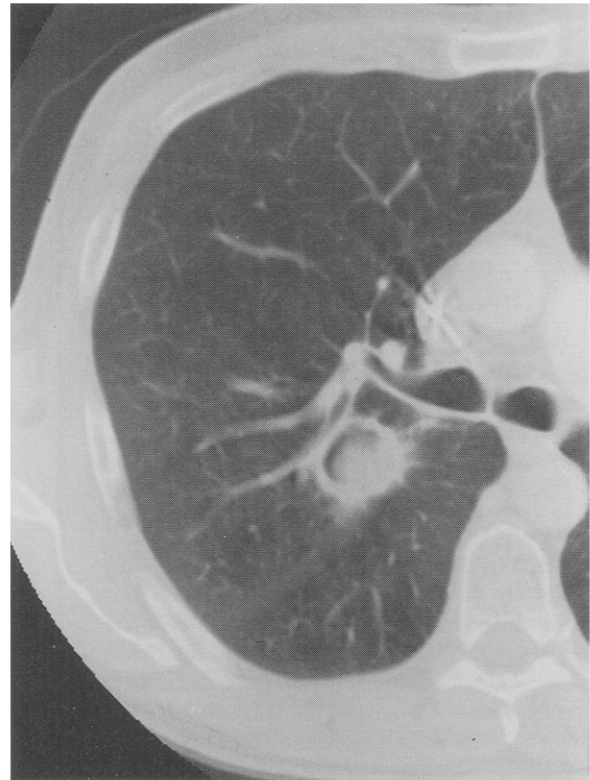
Contrast-enhanced chest CT image from patient No. 8 at the level of the carina showing a gas-containing 2.5 cm diameter cavitory density in the right upper lobe. There is an intracavitary mass and an "air crescent" sign. Other more caudad images (not shown) demonstrate a direct bronchial communication with the cavity and apparent extension of this mass across the major fissure into the superior segment of the right lower lobe (confirmed at operation).
